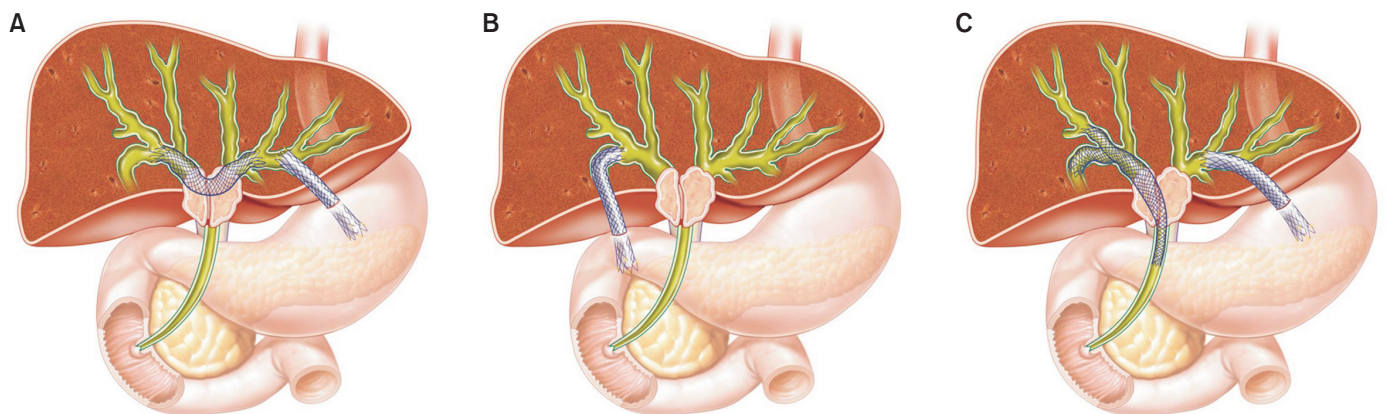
Endoscopic ultrasound (EUS)-guided biliary drainage methods for advanced hilar biliary obstruction. (A) Bridging method. (B) EUS-hepaticoduodenostomy. (C) Combined EUS-hepaticogastrostomy and transpapillary bilateral stenting (modified from Nakai et al⁷⁰).
